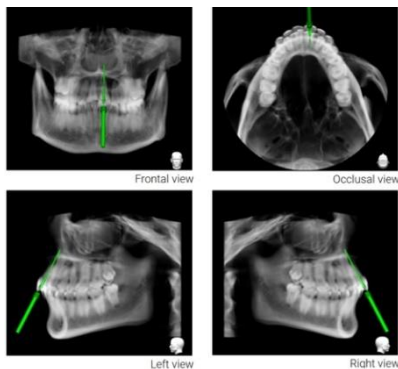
Virtual Planning: The CBCT
